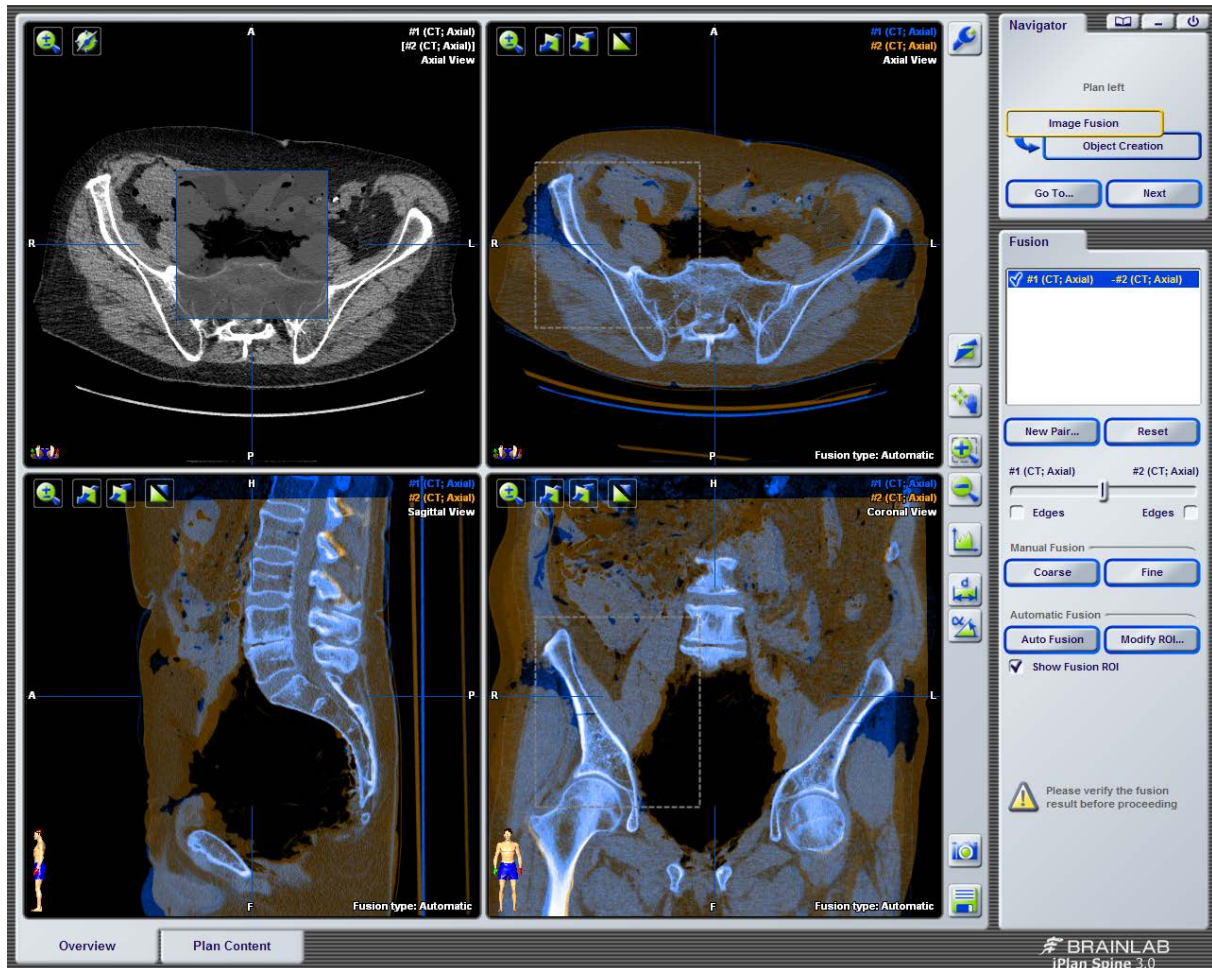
Preoperative and postoperative CT after image fusion
